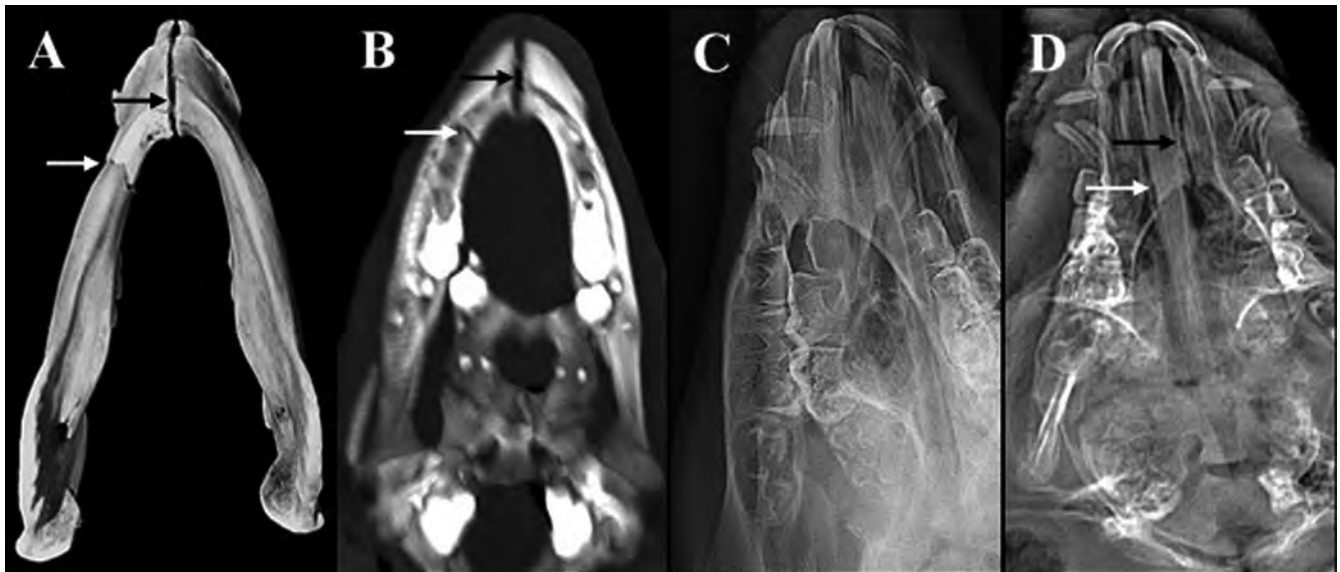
Simple linear fracture of the mandibular body (white arrow) and diastatic fracture of the mandibular symphysis (black arrow) as seen on dry bone (A), CT (B), and Lodox[®] (D), but not visible on X-ray (C)
